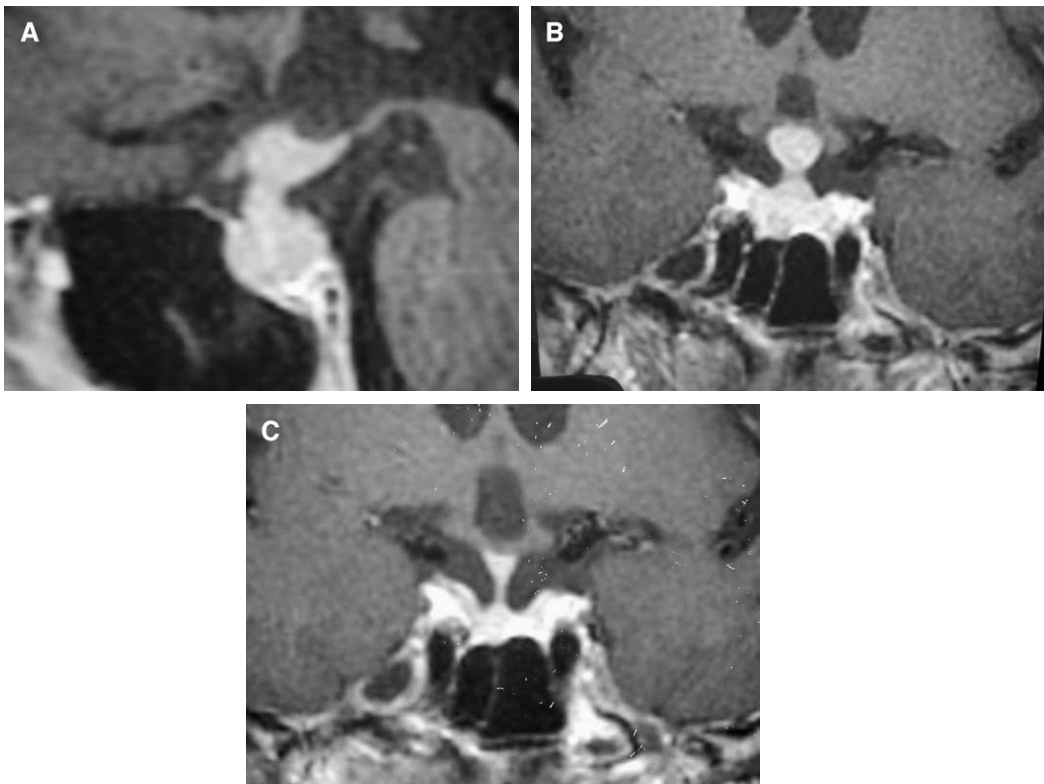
Histiocytosis. (A) Sagittal postcontrast T1-weighted image demonstrates an enhancing mass in the suprasellar region involving the infundibulum. (B) Coronal postcontrast T1-weighted image shows an enhancing mass in the suprasellar region along the infundibulum. Compression of the optic chiasm is seen. (C) Coronal postcontrast T1-weighted image obtained 3 months later after treatment shows a significant decrease in the size of the mass lesion along the infundibulum.
